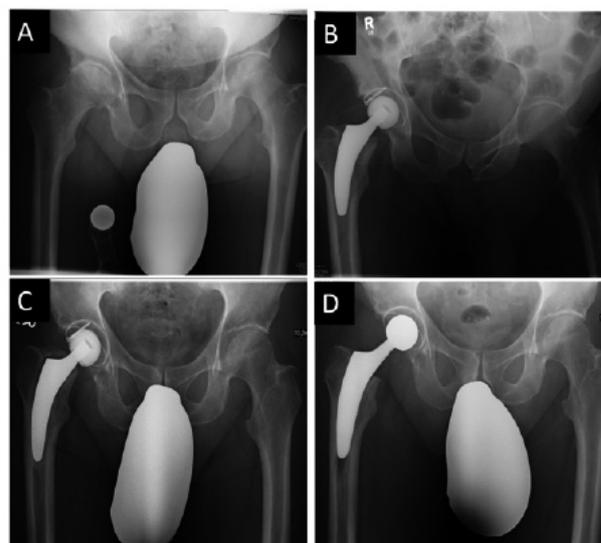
Pelvic radiographs of a 58 years old male patient. (A) Radiograph before surgery. (B) First day after surgery. (C) 16 months after surgery, showing aseptic loosening. (D) After revision surgery and implantation of an optimys stem with a larger diameter.
